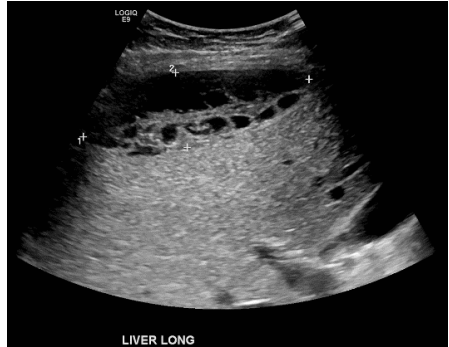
Ultrasound shows a lentiform, loculated fluid collection (11.3 x 9 x 3cm) consistent with a subcapsular liver haematoma.*
